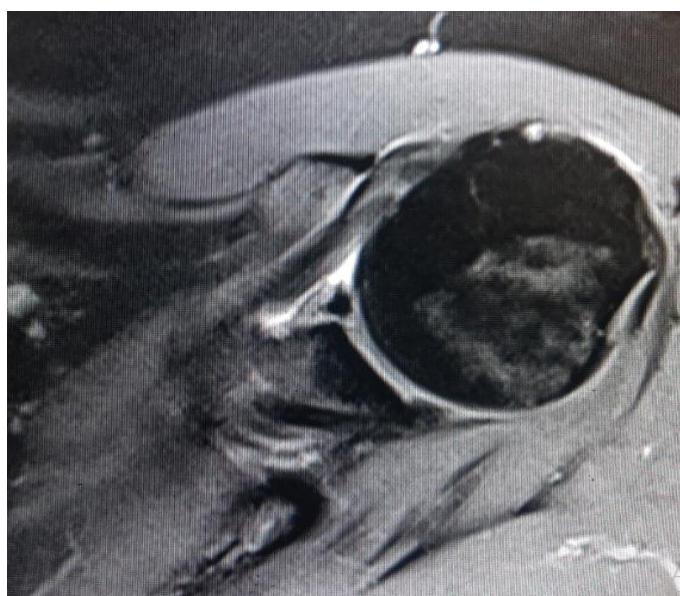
Axial MRI shoulder image revealing anterior –inferior labral tear characterized as Perthes lesion.
